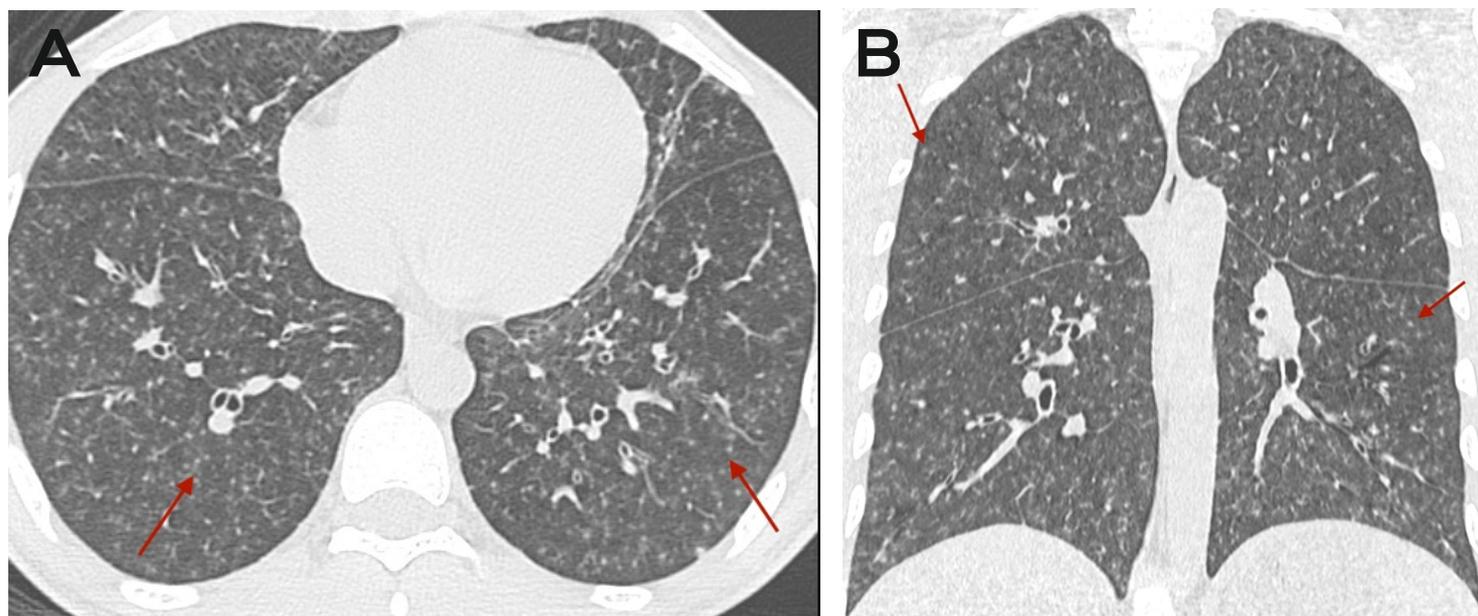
(A, B): Tropical pulmonary eosinophilia (TPE). Axial (A) and coronal (B) HRCT scans of the lungs show widespread, ill-defined bronchocentric nodules typical of TPE.
